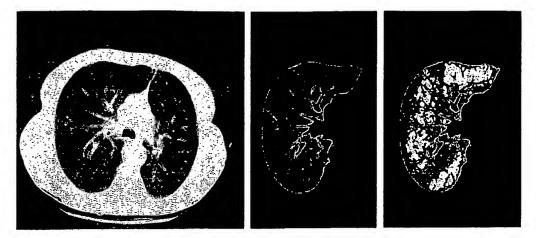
Computerized segmentation of a CT scan image. Original CT scan image (*left panel*). Isolation of the right lung (*middle panel*). Separation of the right lung into severely emphysematous and functioning regions using a CT attenuation threshold of -910 HU (*right panel*). The fraction of lung volume that is severely emphysematous (denoted in *white*) is defined to be the EI, while the remaining regions represent the TFLV (*see* METHODS).
